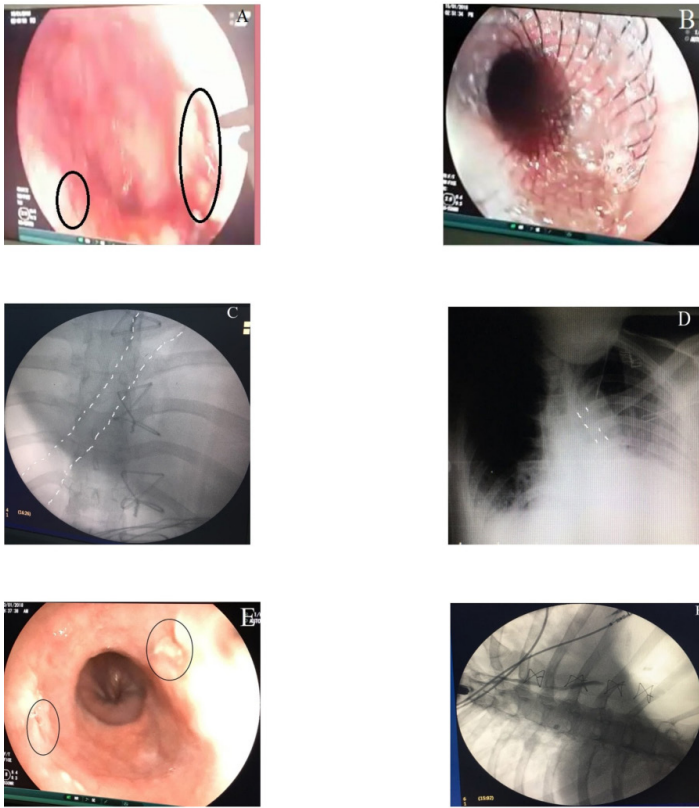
(A) Endoscopic appearance of perforation seen at two different sites distal to esophagus (circled) (B) Full-covered metallic esophagus stent placed in the esophagus, (C) The fluoroscopic appearance of the placed esophagus stent(dashed lines), (D) Appearance of the esophagus stent in the control chest X-ray taken 2 weeks later(dashed lines), (E) Esophageal perforation areas appear to be closed in the endoscopic control(circled), (F) Fluoroscopic view of the esophagus without leakage after pressure contrast with catheter
